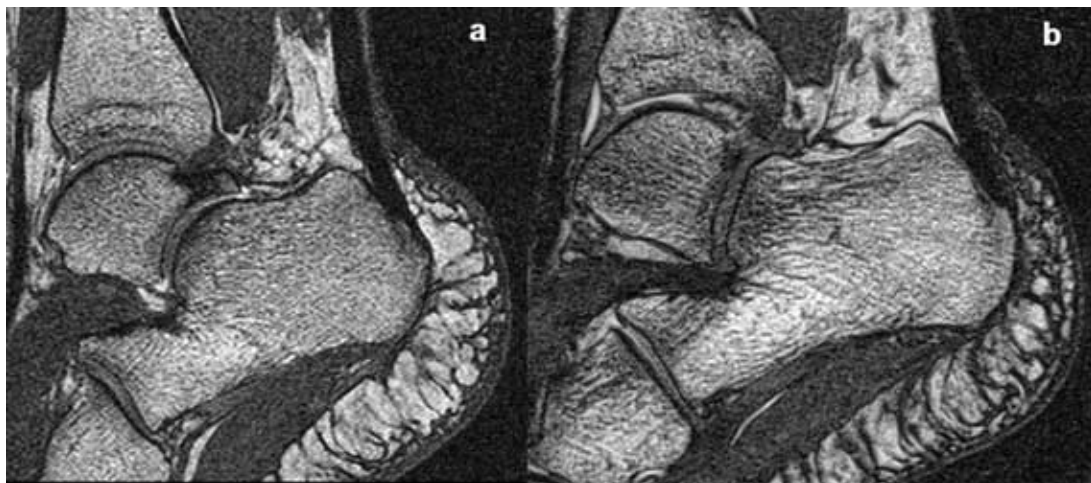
In vivo* high resolution MR images obtained using a 3D Double Echo Steady State (DESS) sequence depicting a sagittal plane for a non osteoporotic (a) and an osteoporotic (b) postmenopausal subject. The pixel in plane resolution is 200 μm X 200 μm and cross plane resolution (slice thickness) is 100 μm . A 10 mm sagittal slab with 10 partitions (1 mm slice thickness) is obtained in a total acquisition time of 4 mins. Note the heterogeneity in the trabecular bone structure, with marked anisotropy in the subtalar region as compared with the more uniform posterior region. These effects are more pronounced in the osteoporotic (b) rather than the non osteoporotic (a) subject.
